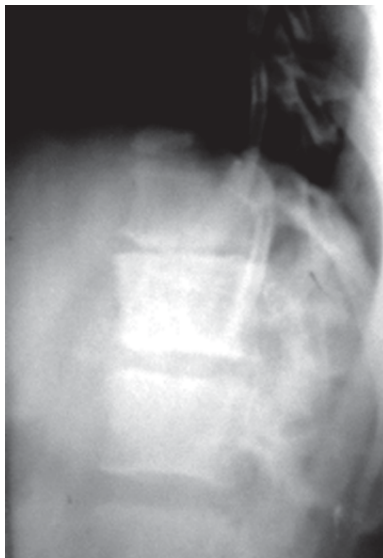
Lateral view of XRay showing reduced disc space of T12-L1 vertebra.
